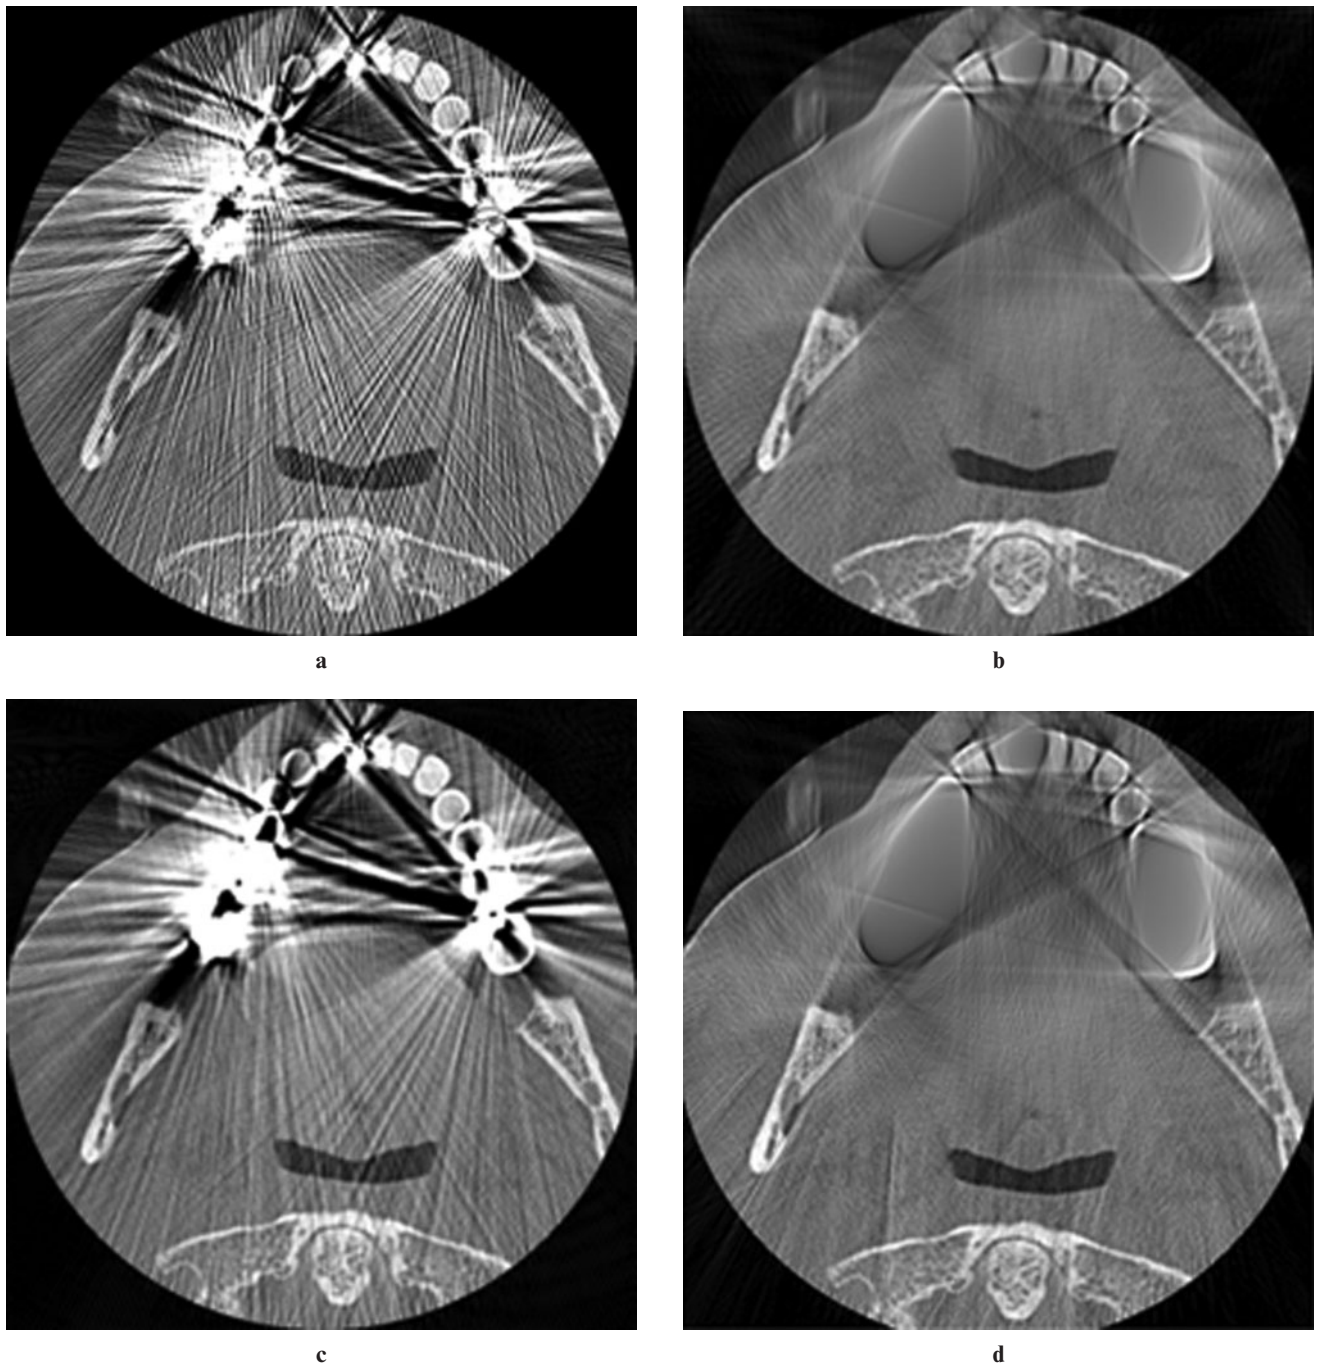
Visual comparison of the efficacy of several metal artefact-reduction algorithms. (a) Original dental CT image containing metal artefacts originating from several metal restorations. (b) Method of Kalender *et al.*⁹ (c) Method of Takahashi *et al.*¹² (d) Method of Watzke and Kalender¹⁶
